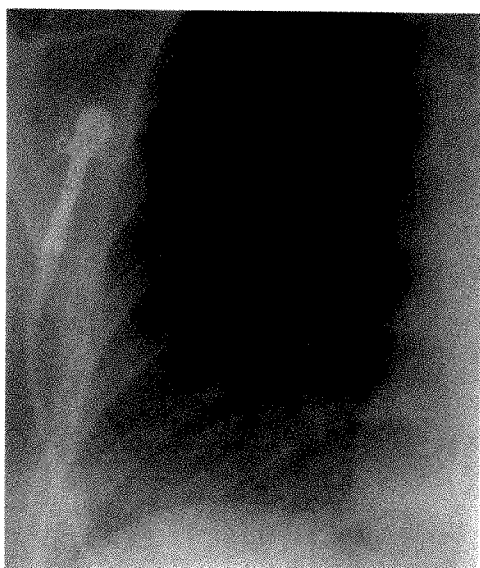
27-year-old woman with metastatic melanoma. Chest radiograph obtained 4 days after start of interleukin-2 therapy shows ground-glass opacities, peribronchial cuffing, and indistinct vascular margins indicative of interstitial pulmonary edema.
